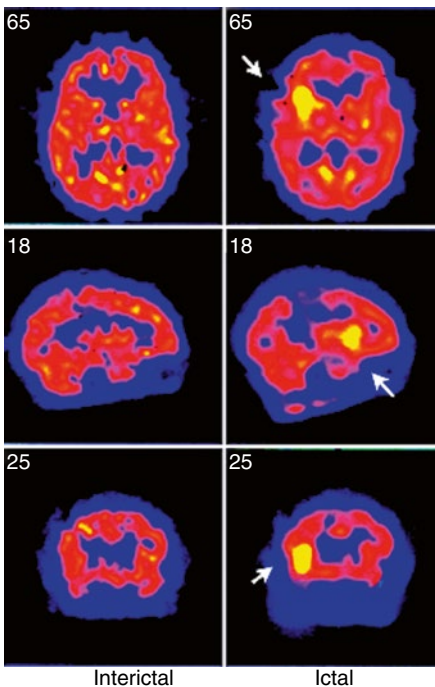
Interictal and ictal ^{99m}Tc -ECD SPECT reveals focal ictal hyperperfusion in the right parietal region (arrows)
